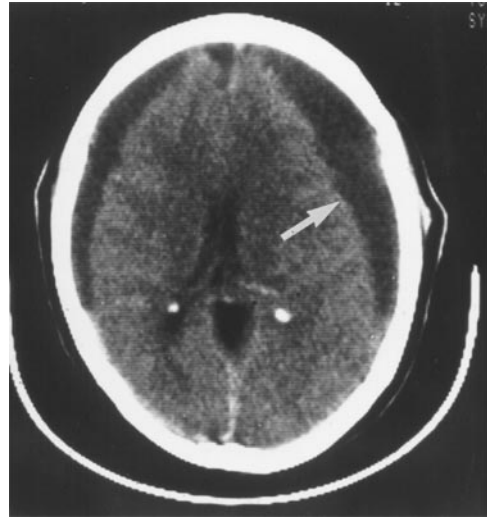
CT scan demonstrating bilateral hypodense subdural hematomas. The one on the right (*arrow*) is chronic; note lens shape. The one on the left is subacute; note how it follows the contour of the convexity.
